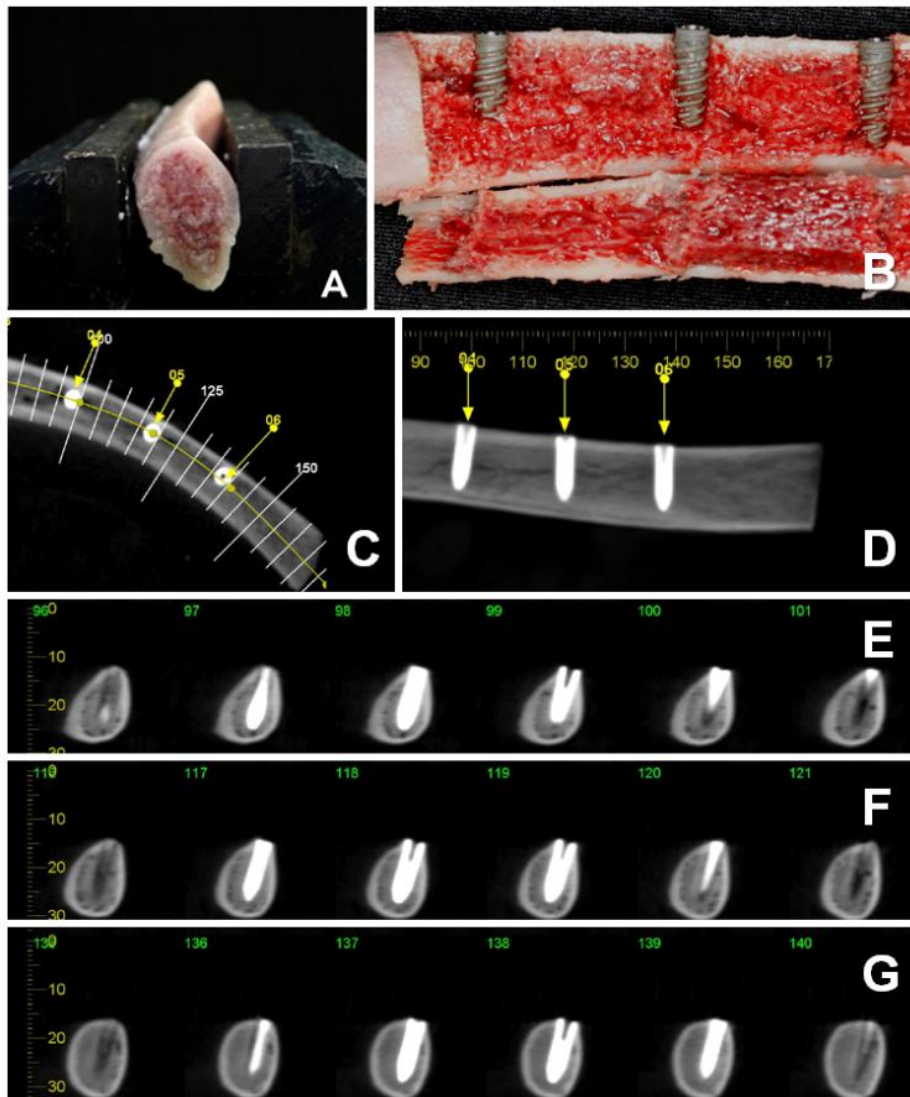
(a) Pork rib. (b) Pork rib of Drive implants sectioned. (c, d) transversal CT of Titamax EX implants. (e, f, g) axial CT of pork rib with Titamax EX implants.
